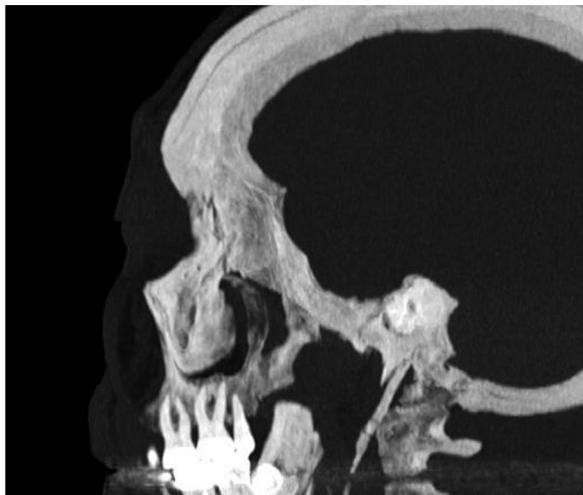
CT scan showing a 57 mm left styloid process.
